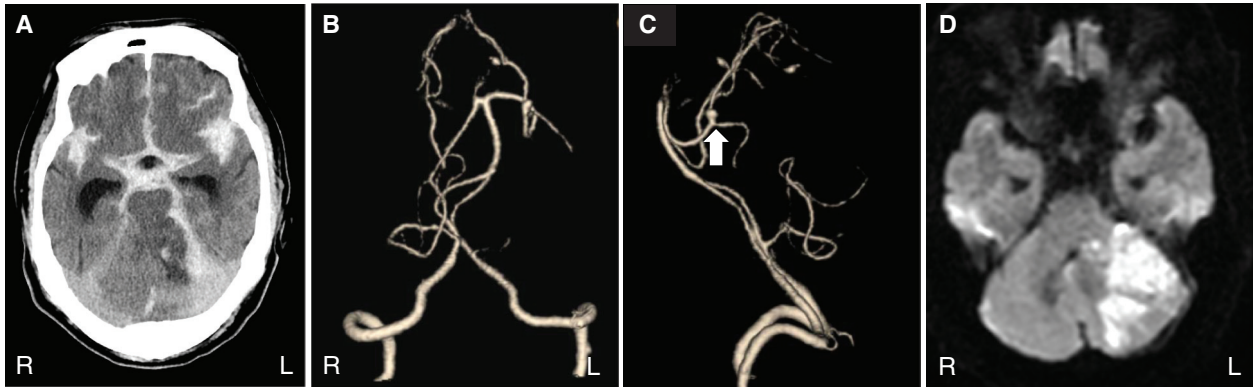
Preoperative CT and DWI images. (A) CT scan revealing subarachnoid hemorrhage surrounding the brainstem. Angiography revealing the aneurysm in the distal SCA: (B) frontal view, (C) lateral view (arrow), (D) DWI revealing infarction in the SCA territory. CT: computed tomography; DWI: diffusion-weighted imaging; SCA: superior cerebral artery
